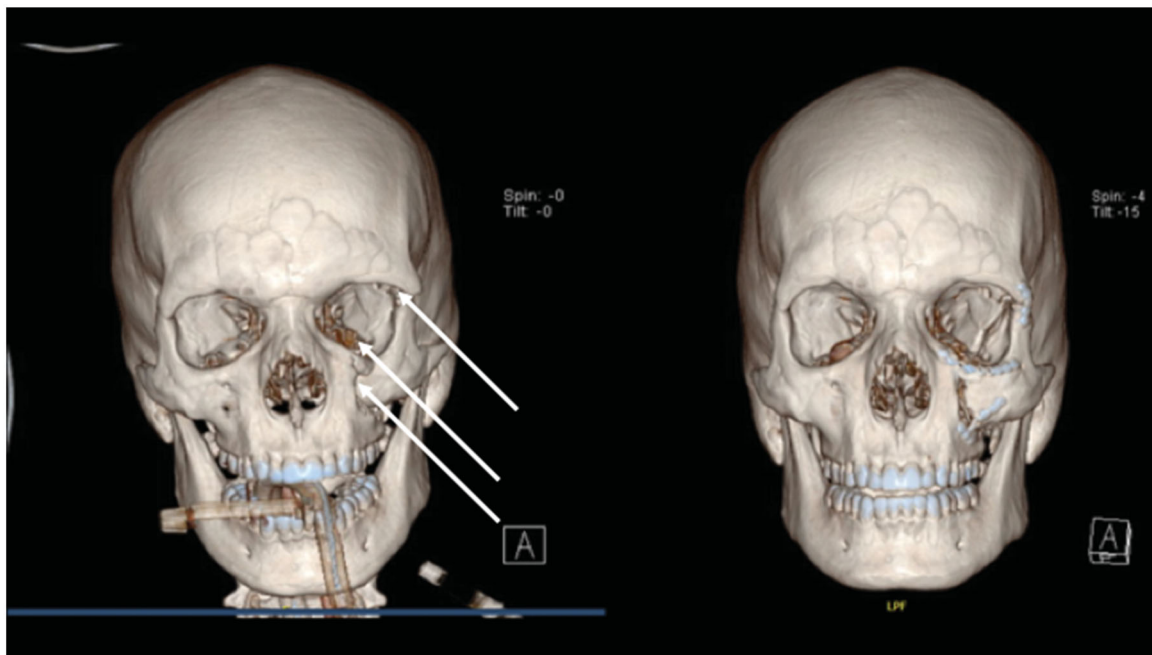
Pre- and postoperative CT-Scan depicting a ZMC fracture. The separate fracture lines are marked with arrows in the preoperative scan. On the postoperative scan the fractures lines are bridge with plates.
